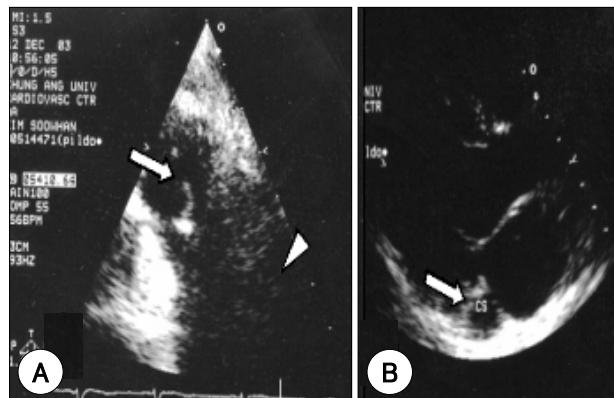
The 2D-Echocardiogram. A: parasternal short axis view; thickened, dysplastic partially bicuspid pulmonary valve (arrow) and marked dilatation of the main pulmonary artery (arrow head). B: parasternal long axis view; huge coronary sinus (arrow) along the posterior side of the left atrium.
